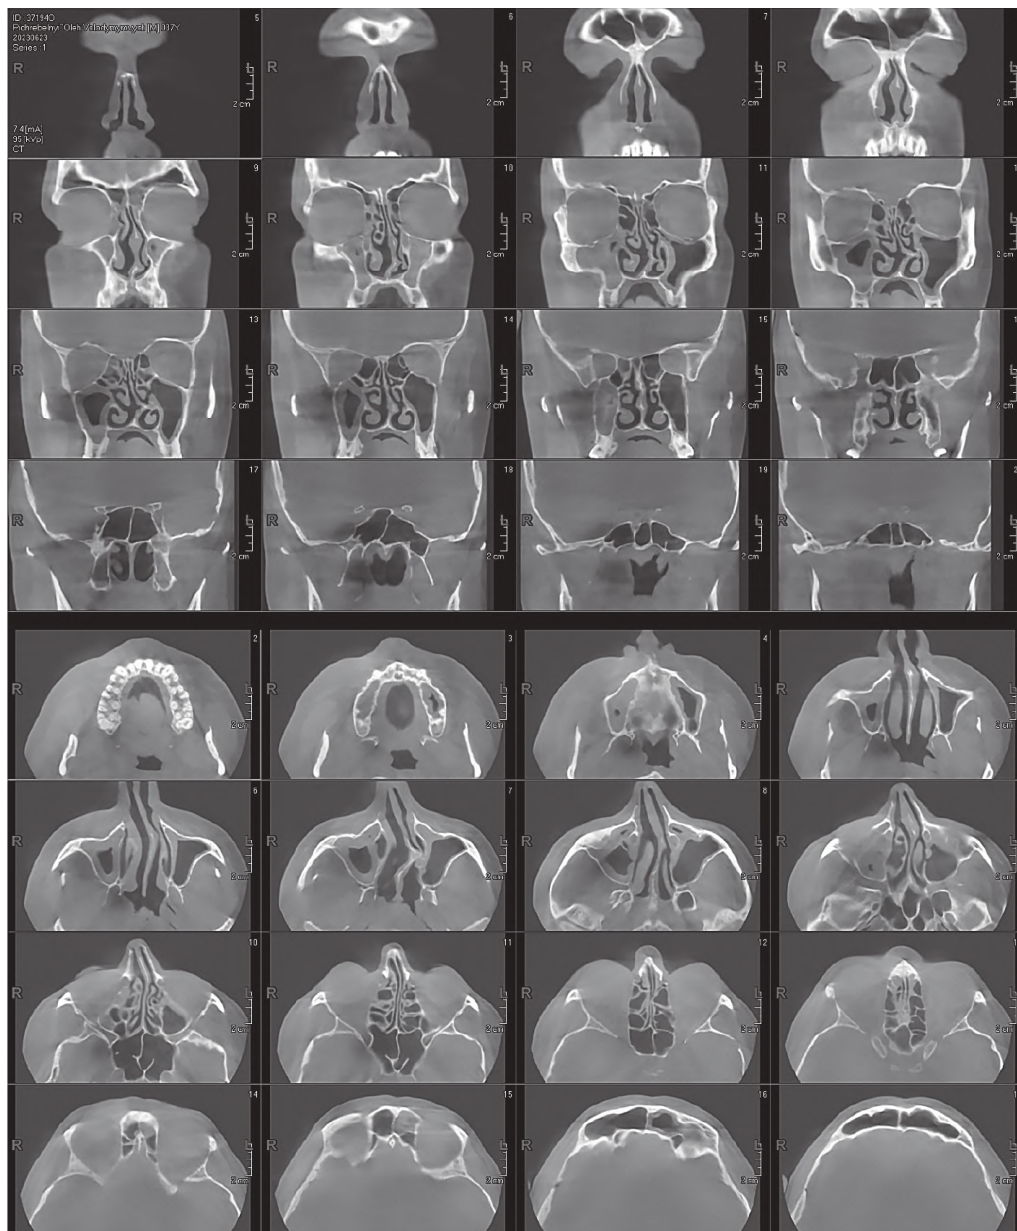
Figure – Computed tomogram of the front part of the head. KPKT-signs of frontal and maxillary-sinusitis changes, deformation of the septum on the left with the formation of a prominent bone ridge. The patient is 38 years old.
